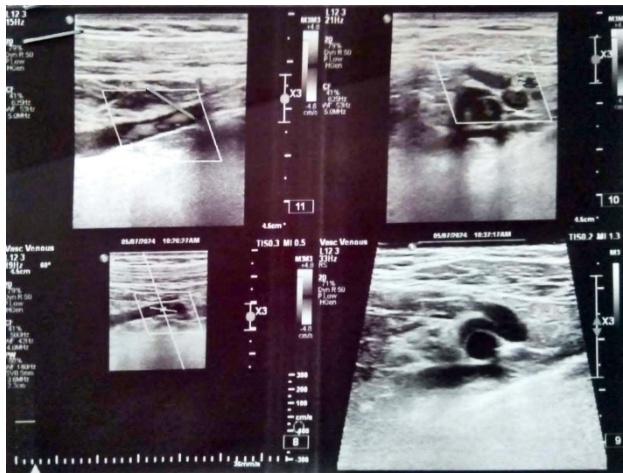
Venous Doppler study showing complete resolution after 3 months.
